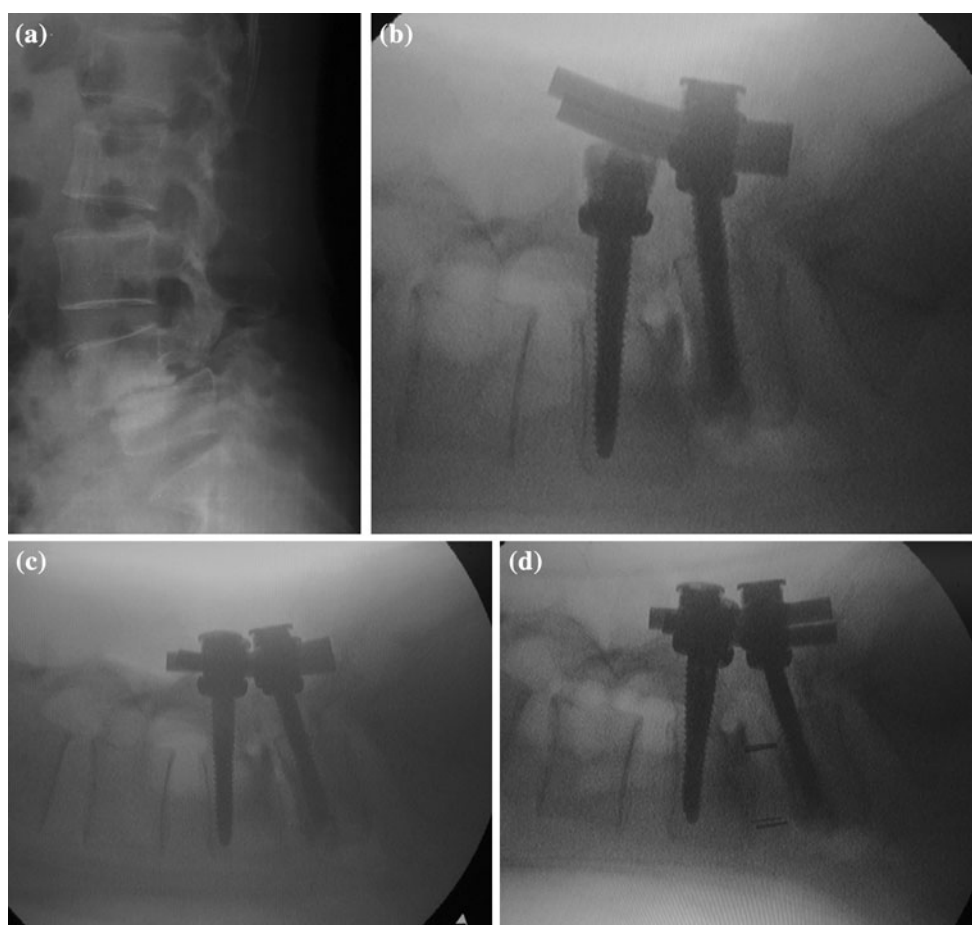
Surgical procedure performed intraoperatively in a 51-year-old woman with grade II isthmic spondylolisthesis at L4–5. a Preoperative lateral X-ray showed grade II slippage and interbody space collapse. b Pedicle screws were inserted at L4–5, the rods were
